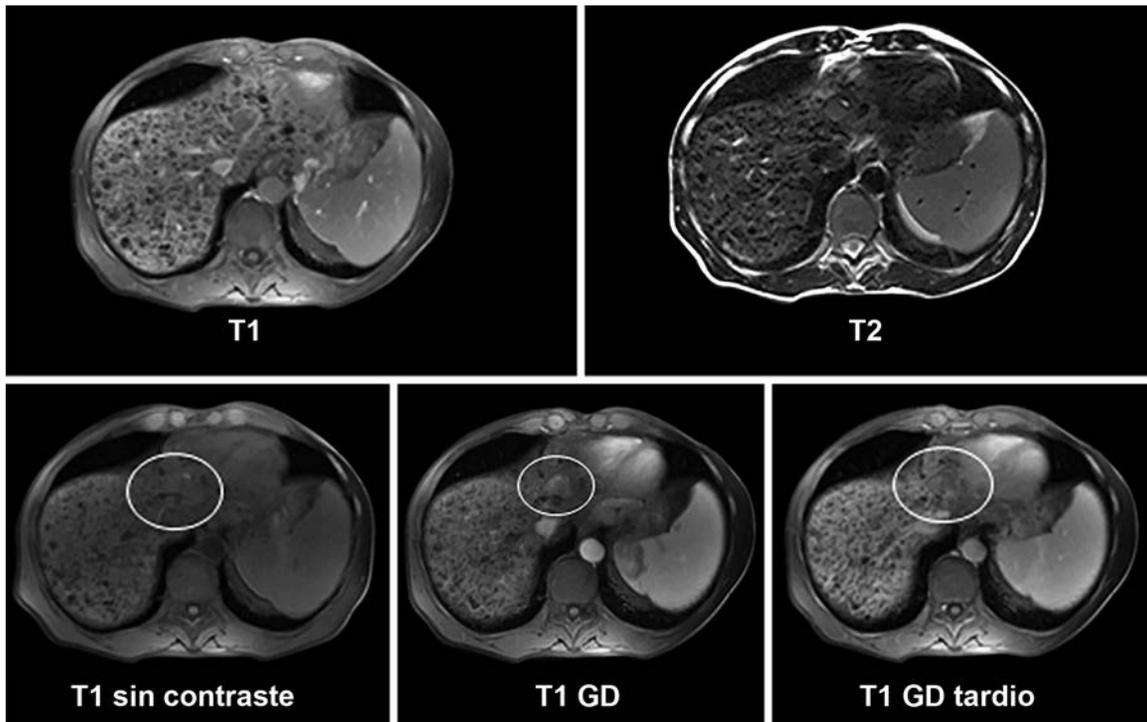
Thoracoabdominal MRI scans.
